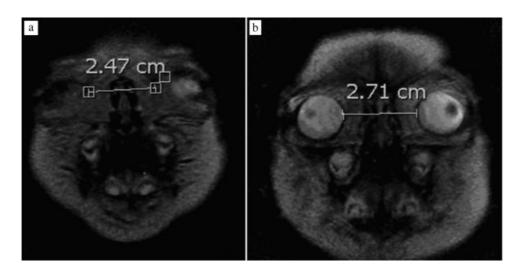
MRI-coronal section of the head demonstrating the intercanthal folds (a) and the bony interorbital distance from the medial globes (b). MRI, magnetic resonance imaging.
